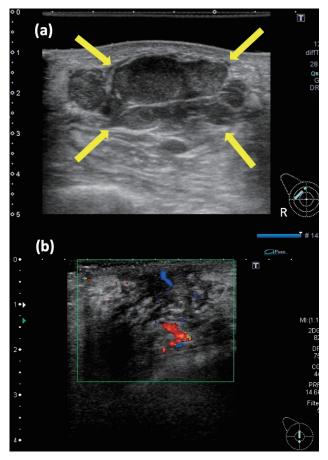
Ultrasound of the breast at the first visit. (a) A hypoechoic mass of  $83 \times 25 \times 49$  mm in the right C region (yellow arrow) and a mass  $68 \times 12 \times 41$  mm in the AB region were observed. (b) A pulsatile blood flow signals were observed inside the tumor.
